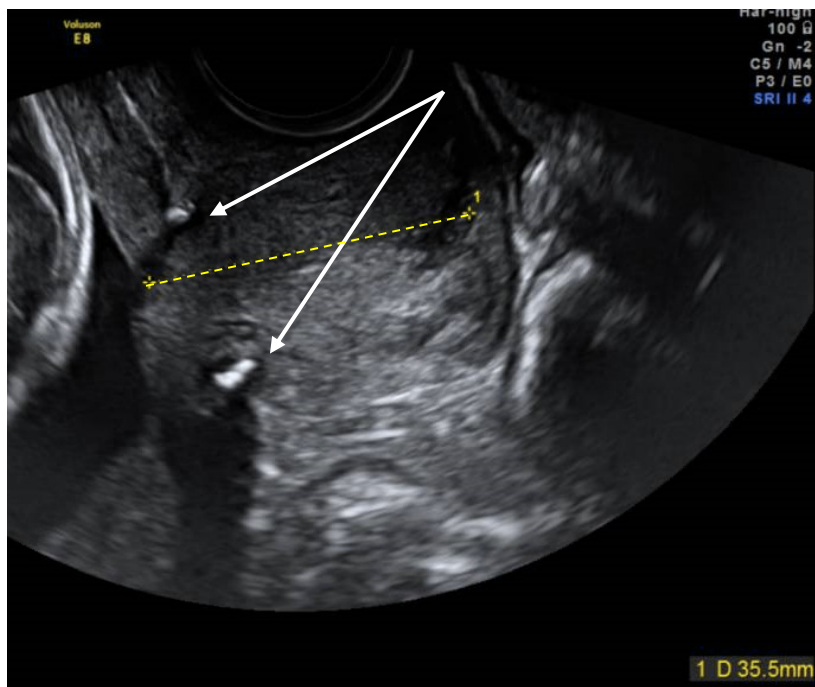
Transvaginal ultrasound of transabdominal cerclage. Transabdominal cerclage at the level of the internal os by transvaginal ultrasound with cervical length of 35 mm.
